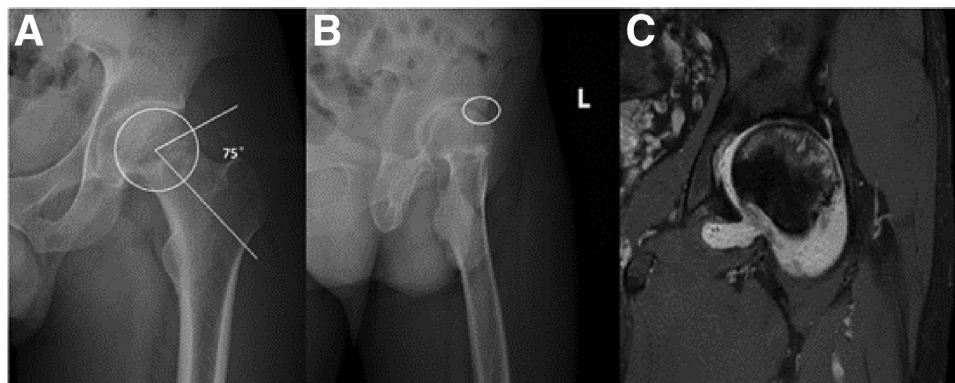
Preoperative anteroposterior (AP) (A) and lateral (B) radiograph and coronal magnetic resonance image (MRI) (C) of the left hip. (A) AP radiograph shows the subchondral fracture of the left femoral head, local osteoporosis, local cystic change, flattening of the articular surface of the femoral head, and the collapse of the femoral head less than 2 mm, which are Association Research Circulation Osseous stage III manifestations of femoral head necrosis, $\alpha = 75^\circ$. (B) Lateral radiograph shows the cam-type impingement. (C) Coronal MRI of the left hip shows the intramedullary bone marrow edema, subchondral fracture, and crescent sign.
